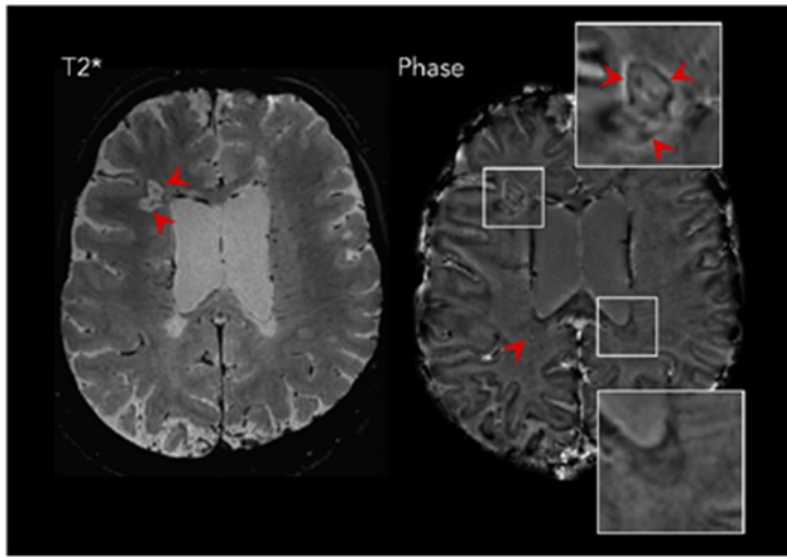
Representative MRI images of PRL in MS. Axial 3-tesla T2*-weighted magnitude and phase MRI images from a relapsing remitting MS patient (40 years old, male) showing PRL (arrowheads). Insets show magnified views. Adapted from [34]
